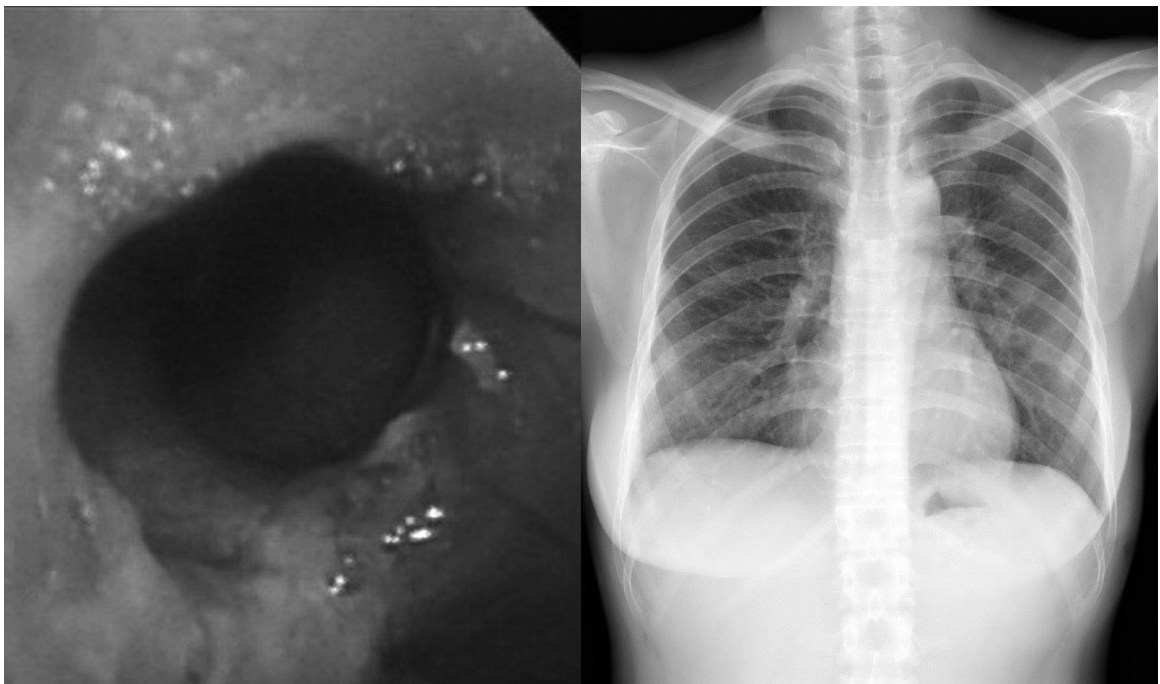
A. Follow-up bronchoscopy on PTD 54. B. Chest x-ray at final clinic visit on PTD 65 showed the left lung was expanded fully.
